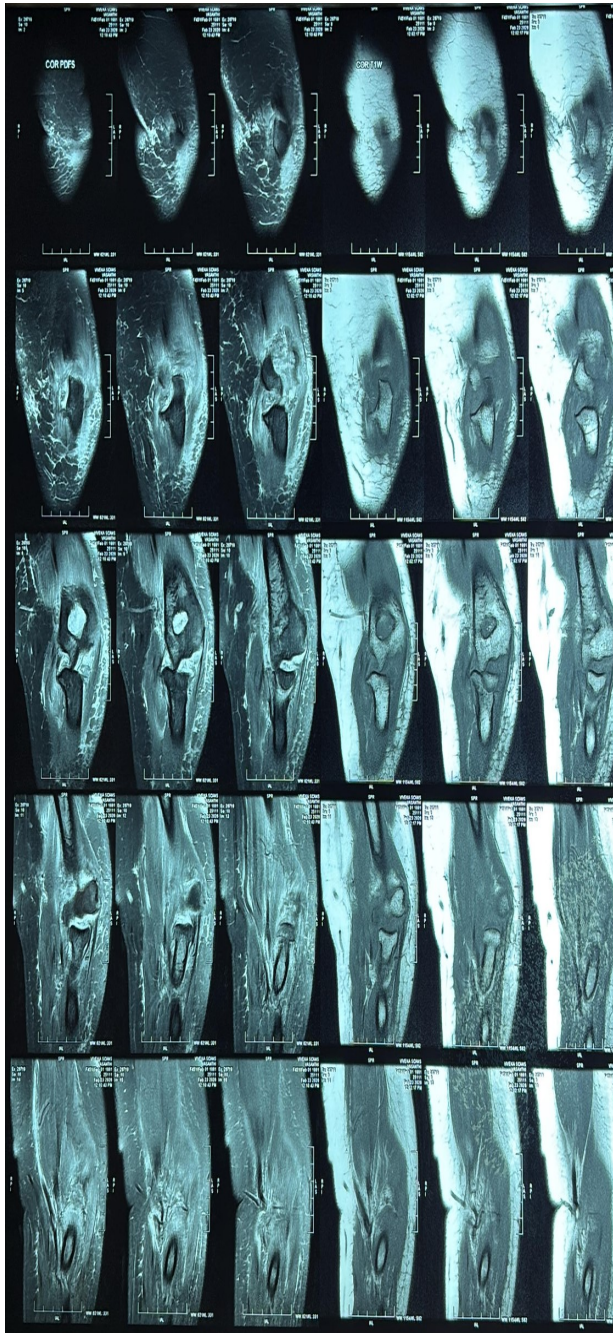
MRI left elbow — coronal PDFS and T1W sequences confirming full-thickness tear of the lateral collateral ligament complex and high-grade near full-thickness tear of the medial collateral ligament complex.
